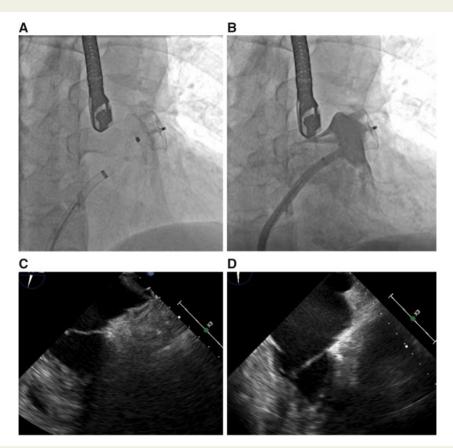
A final fluoroscopy and angiographic image after device release (A and B), final device position on transoesophageal echocardiographic (C), and repeat transoesophageal echocardiographic images 6 weeks later (D). TOE, transoesophageal echocardiography.
